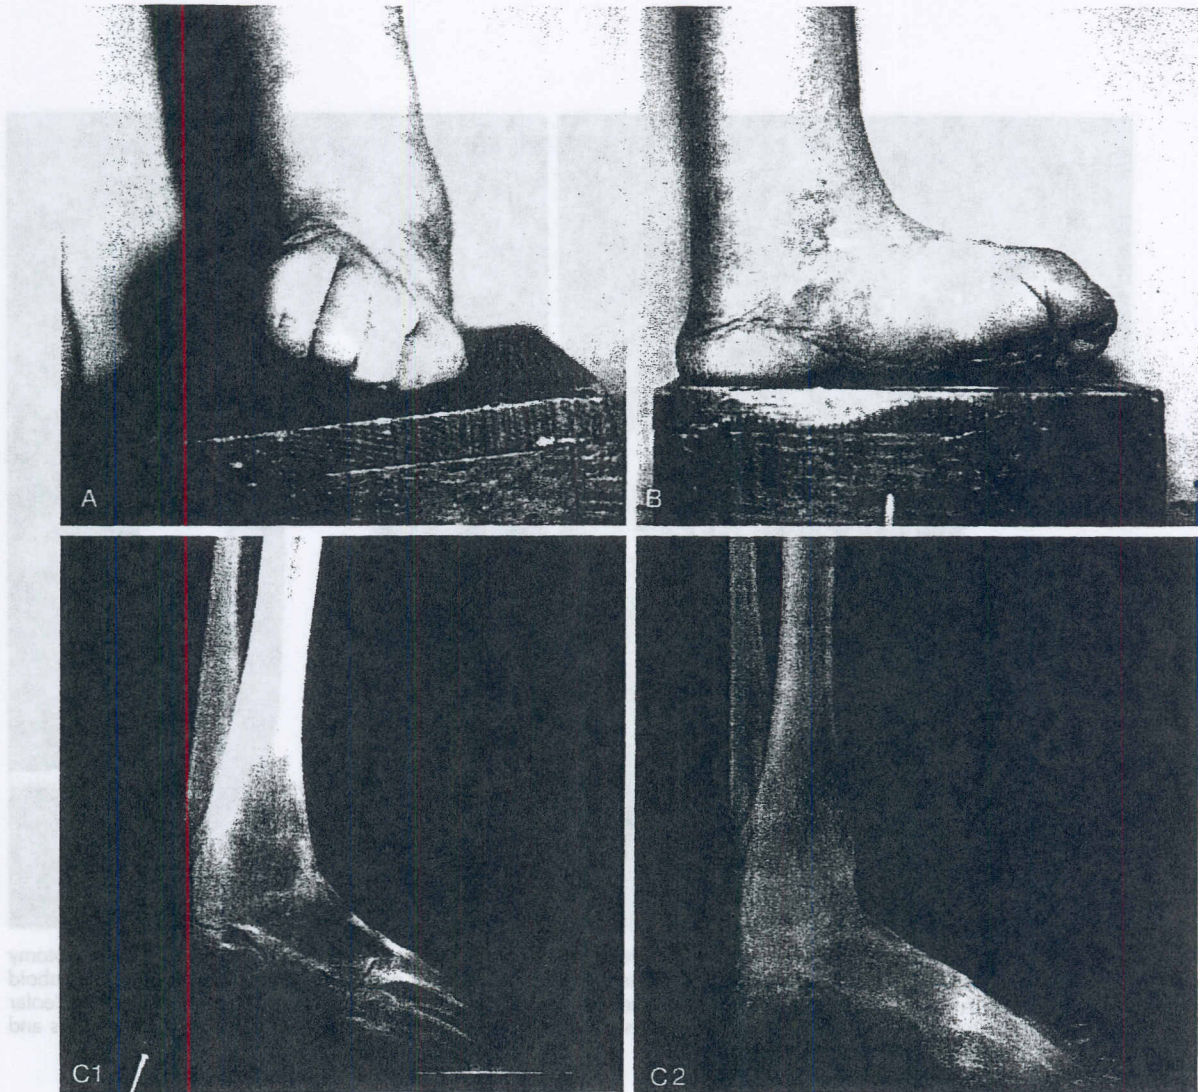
(A and B), Frontal and side views of the leg and foot of a 63-year-old man who suffered an injury at the age of 6. He was previously told that nothing could be done to correct the very severe supination deformity of the forefoot and equinovarus malunion of his ankle arthrodesis. (C1), Note the anteroposterior forefoot appearance on this lateral preoperative radiograph. (C2), At the end of correction, the lateral radiograph appears normal.
